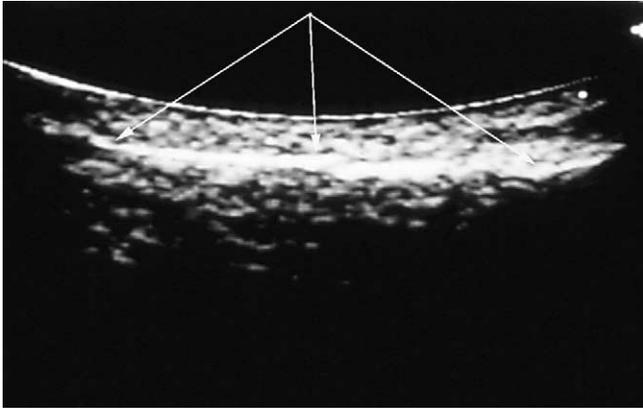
Ultrasound image of the normal anatomy of the infraorbital rim. The arrows show the convex structure of the infraorbital rim.
